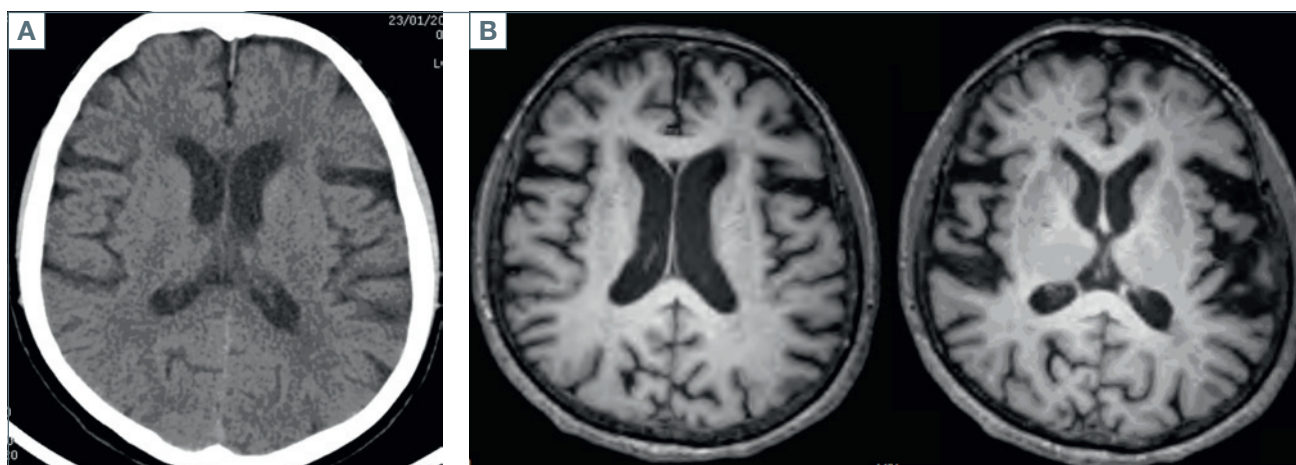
A. Brain CT showing off the slight enlargement of bilateral frontal horns of the lateral ventricles. B. Brain MRI: the frontal and temporal atrophy.
